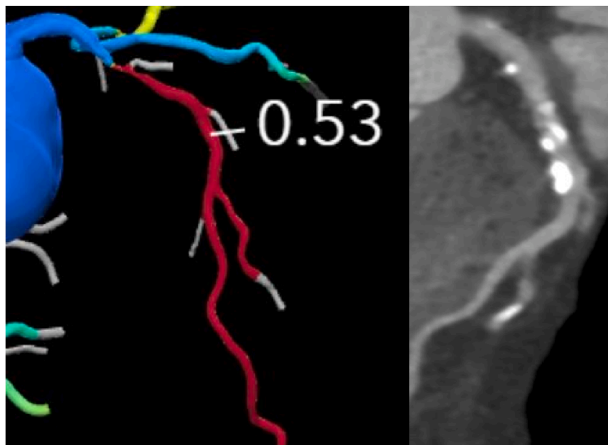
CAD-RADS 4A/P2/I+: A severe (70–90% diameter stenosis) in the proximal LAD artery with a stenosis specific value of 0.53 and high translational delta CT-FFR (0.40 – from 0.93 pre stenosis). This pattern of focal disease is amenable to percutaneous intervention.
